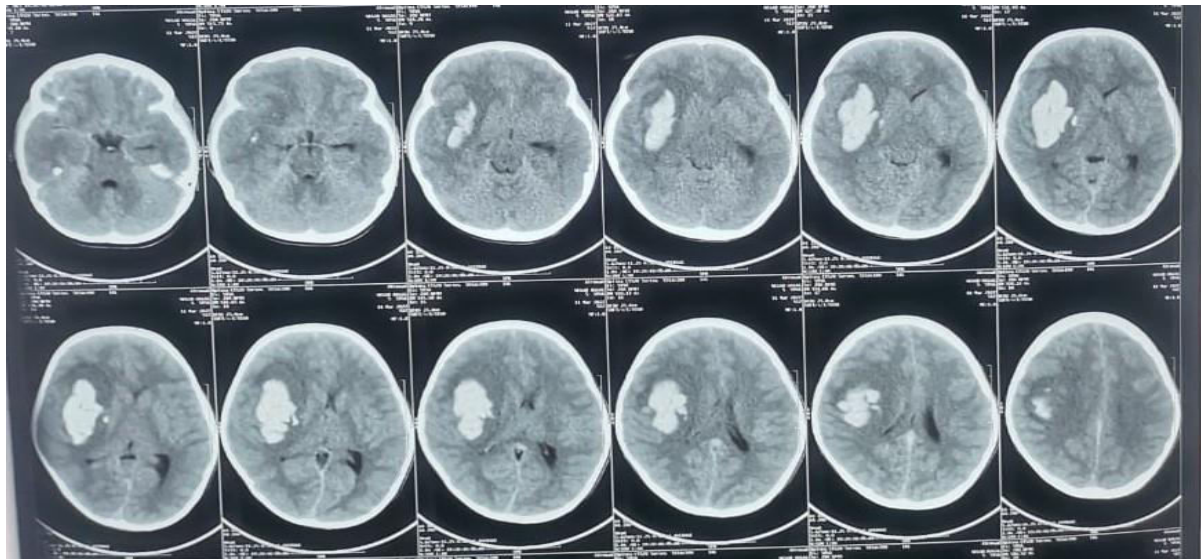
CT head, brain window, axial view , showing rt paritotemporal ICHge around 25 cc with mild ventricular compression without midline shift or hydrocephalic changes
